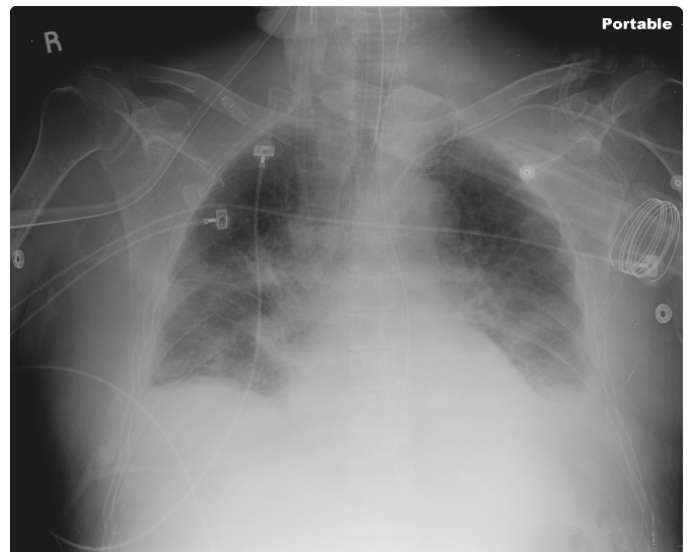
Chest radiograph from hospital day two shows bibasilar patchy opacities along with left greater than right small pleural effusions and edema. This image is significant for enlarged and indistinct hila with a blurring of the outline of the pulmonary vessels (which normally have sharp borders on chest radiograph). These findings are consistent with pulmonary edema.
